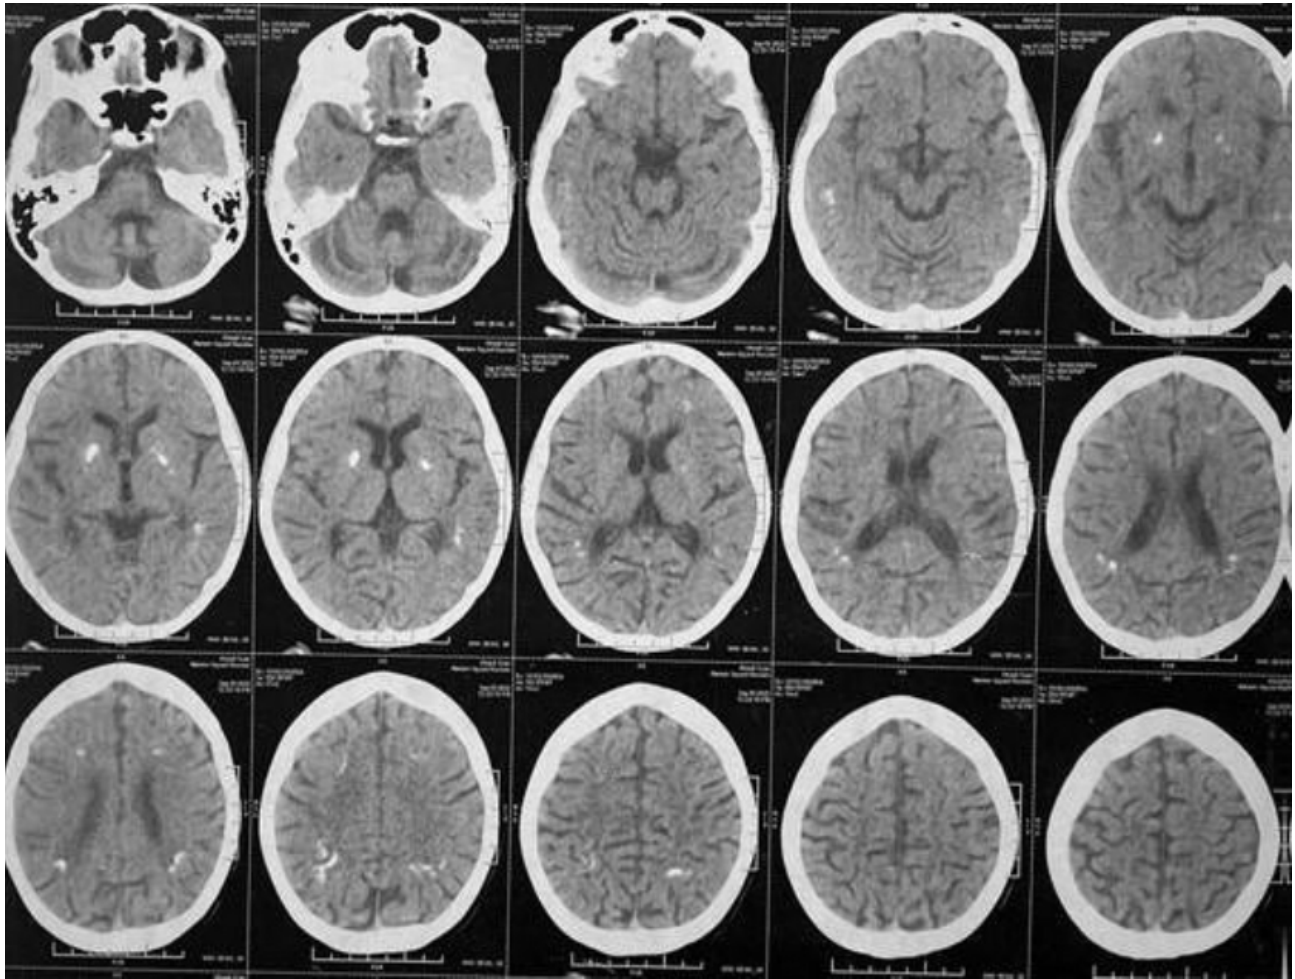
Non contrast multislice CT image showed bilateral basal ganglia and periventricular calcifications together with brain atrophic changes. CT, computed tomography.
